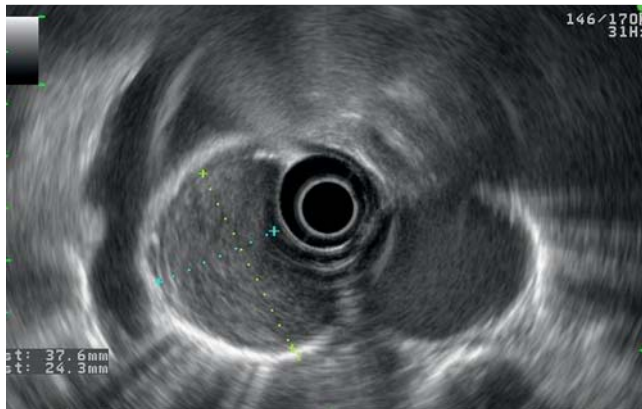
Endoscopic ultrasound (EUS) view of the hypoechoic lesion in the submucosa of the distal esophagus.
